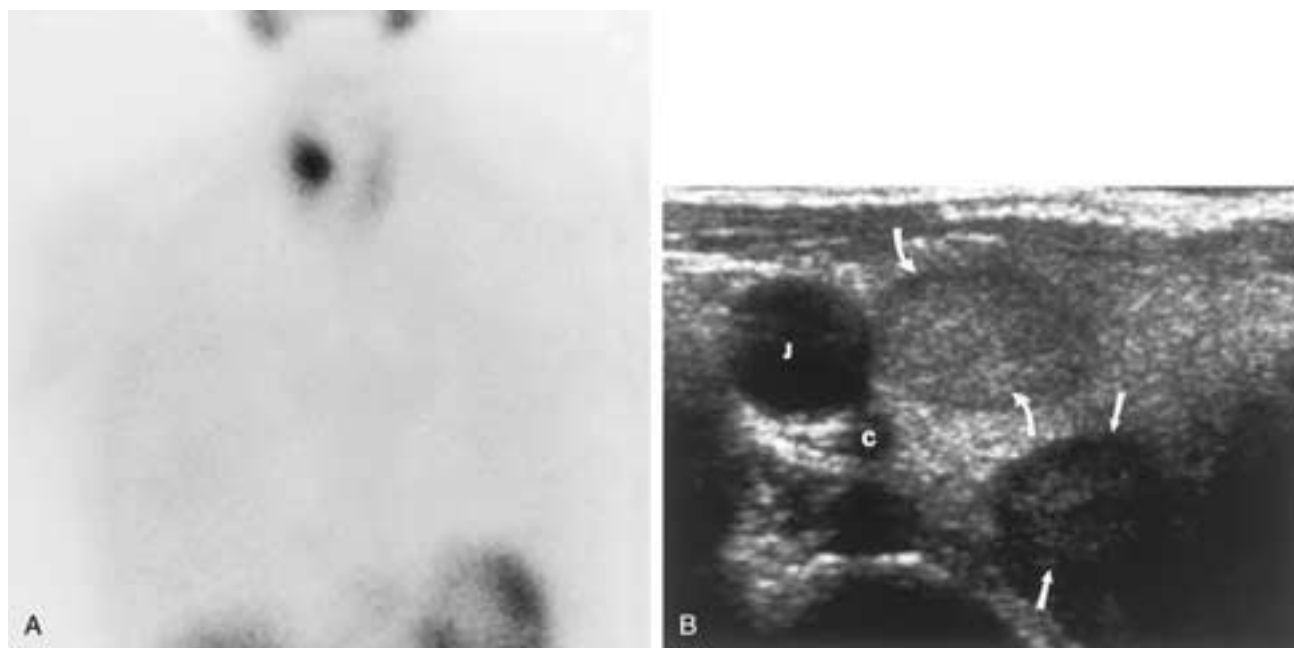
A pitfall in Tc-99m sestamibi scintigraphy is that thyroid lesions may concentrate sestamibi similarly to parathyroid adenomas. A, Sestamibi scan shows increased activity in the right lobe of the thyroid gland. B, Transverse ultrasound image reveals a well-demarcated mass in the thyroid (*curved white arrows*) that at surgery was found to be a thyroid adenoma, as well as a rounded mass hypoechoic to and posterior to the thyroid that was a parathyroid adenoma (*straight arrows*). J, Jugular vein; C, carotid artery.
